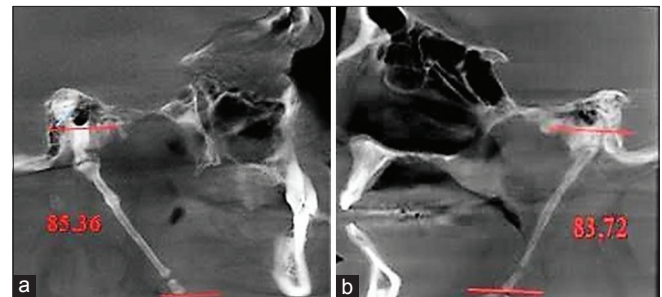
(a and b) The length of the styloid process was measured bilaterally in the cone beam computed tomography sagittal plane
